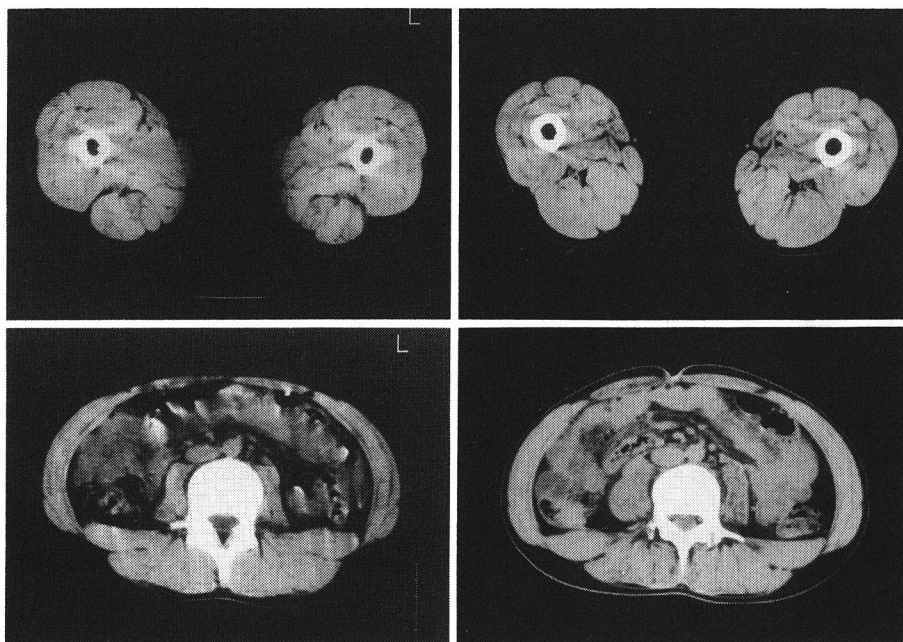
Muscle CT of this case
